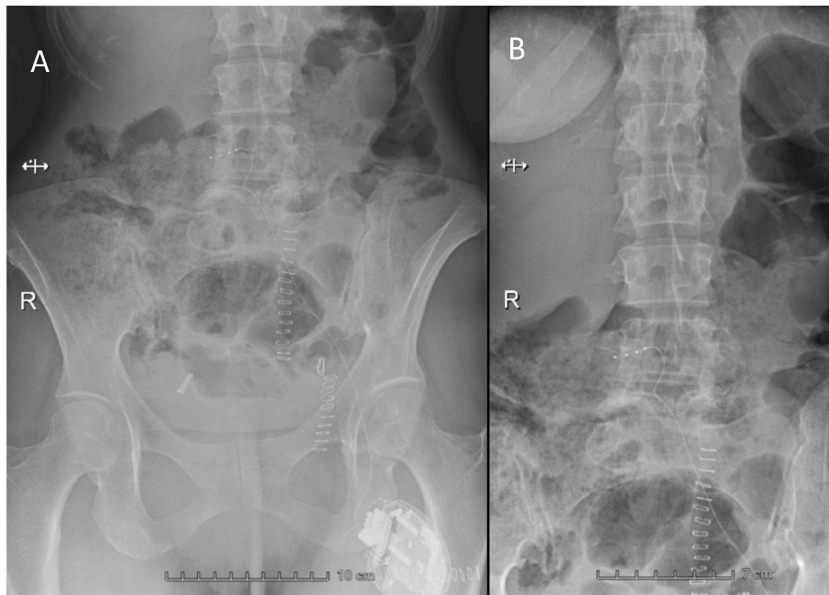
Postoperative lumbar X-ray revealing the IPG in the left fossa (A) with tip of electrode paramedian right at L4-L5 (B).
